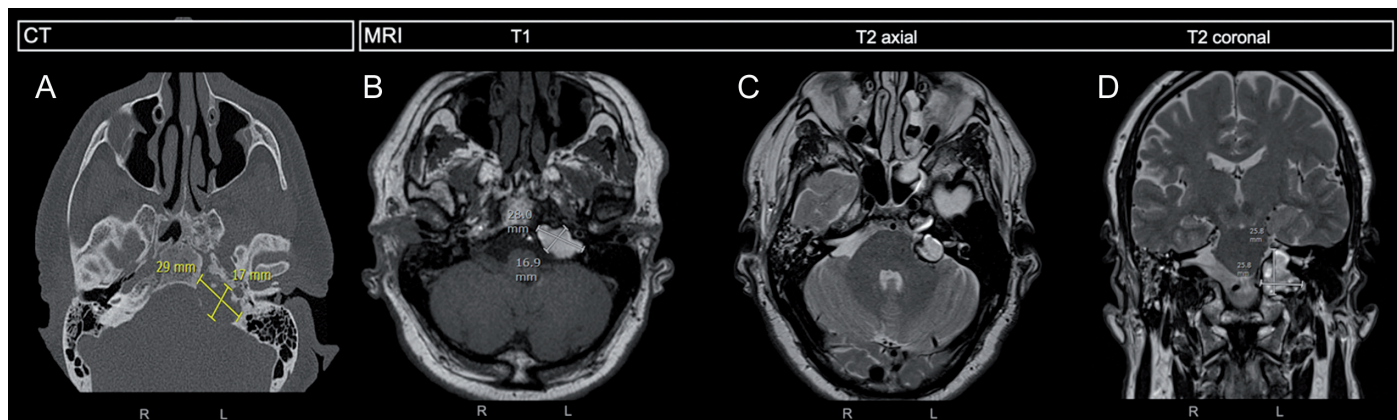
a-d. Preoperative radiologic findings. (A) The axial CT reconstruction, used for navigation, of a low-density expansive mass in the left petrous apex with corresponding radiographic measurements. (B) T1 axial MRI reconstruction with corresponding radiographic measurements. (C-D) T2 axial and coronal MRI reconstruction. (B-C-D) The dorsal margin of the well-circumscribed mass reached the internal acoustic meatus with a clear displacement of the vestibulocochlear nerve. The anterolateral margin remained within the petrous apex, whereas the medial margin expanded toward the lateral side of the internal carotid artery. CT, computed tomography; MRI, magnetic resonance imaging.
